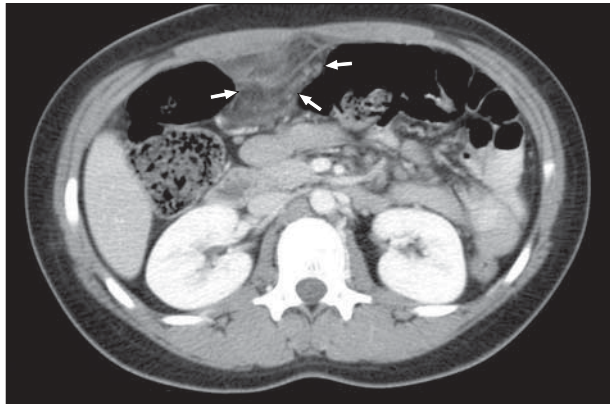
Axial computed tomography through the patient's upper abdomen at the level of the kidneys. Triangular area of radiodense omental fat (arrows) is seen anteriorly within the right abdomen.
